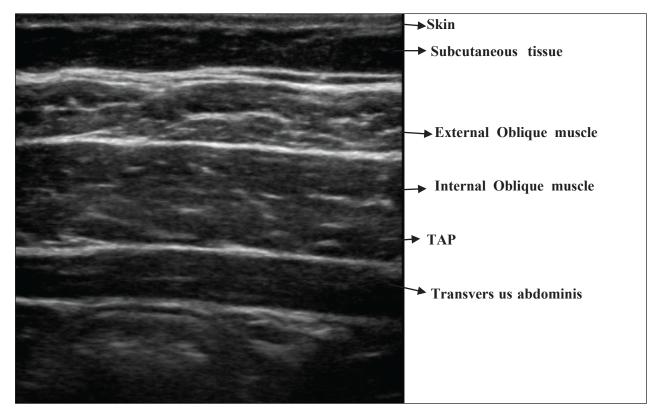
Ultrasound anatomy of TAP block
